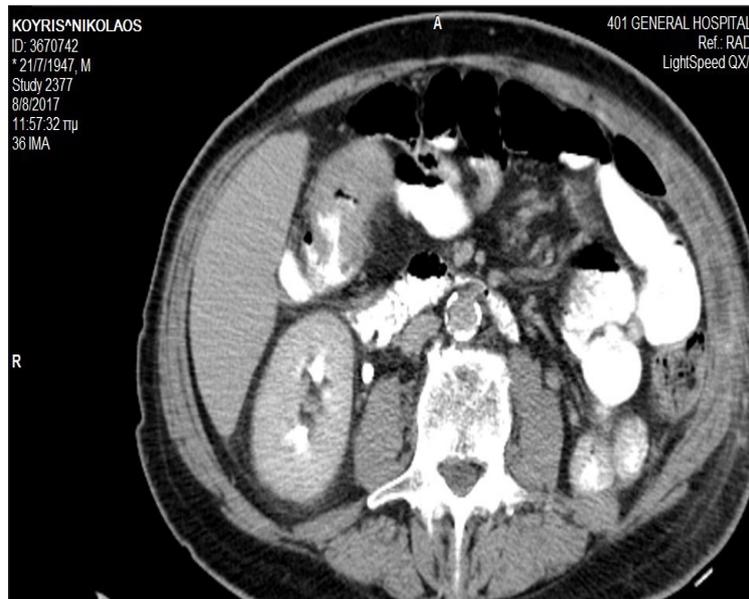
A baseline abdomen CT scan showing thickening of the transverse colon.
